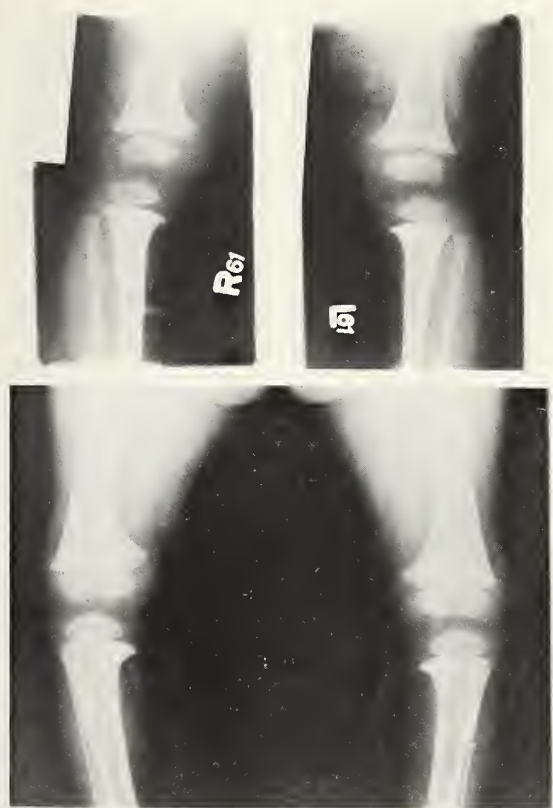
Radiographs of the femoral epiphyses before (above) and after (below) therapy with vitamin D.
